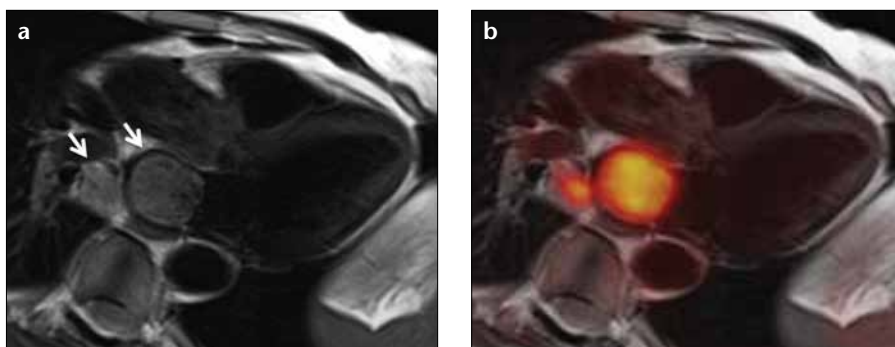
a, b. A patient with central non-small cell lung cancer infiltrating the left atrium via the lower right pulmonary vein (a, arrows). MR images provide excellent anatomical soft tissue contrast and allow for the detection and quantification of potential impairment of functional parameters like ventricular or valvular function or blood flow. Simultaneous FDG-PET can help in determination of malignancy or differentiation of vital tumor from necrotic tissue or thrombus (b).
